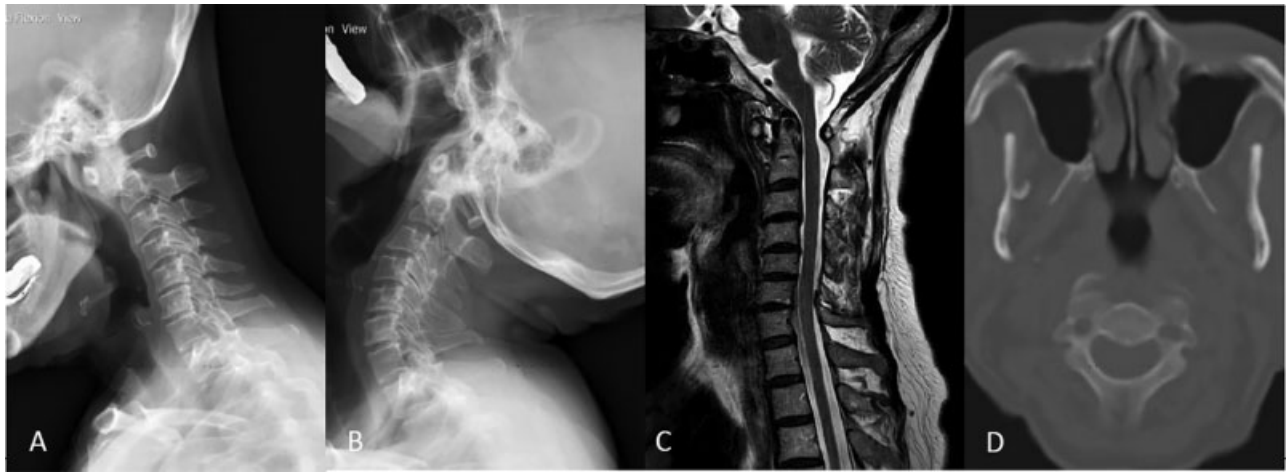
Image of second case, C1–2 subluxation with small C2 pedicles. (A) Flexion view. (B) Extension view. (C) MRI T2 sagittal view, no spinal stenosis at C1–2 level. (D) CT axial view at C2 level. Both pedicles are less than 3.5 mm. CT, computed tomography; MRI, magnetic resonance imaging.
